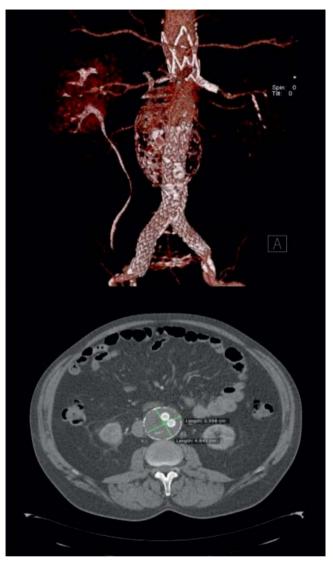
3D image on a 1-month follow-up CTA examination.
